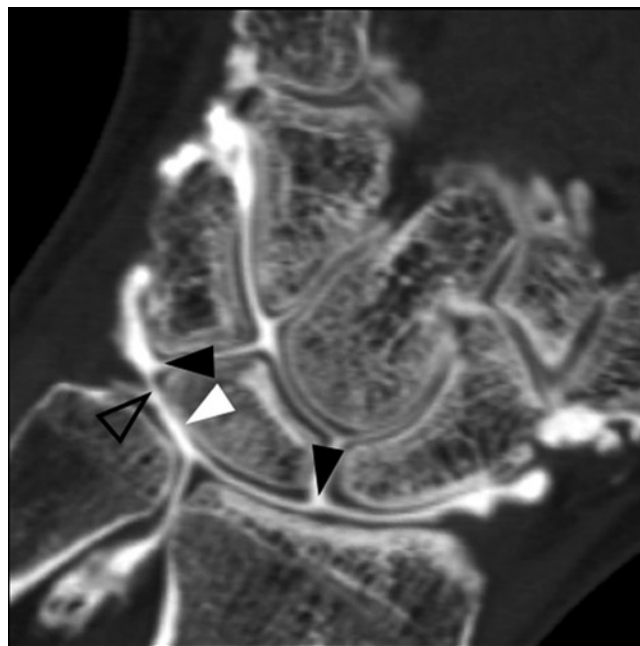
Coronal reformat of a computed tomographic (CT) arthrography of the wrist in a 38-year-old man with a history of trauma shows a grade 4 cartilage lesion of the proximal surface of the lunate (*white arrowhead*). Tear of the interosseous ligaments of the proximal row (*black arrowheads*) and of the TFCC (*open arrowhead*) can also be delineated
